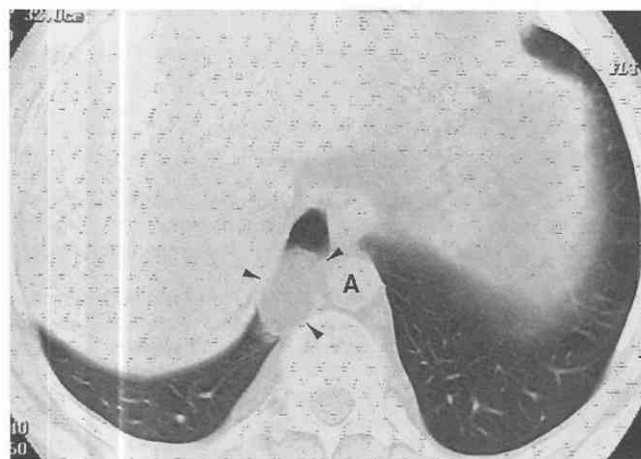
Bochdalek's hernia. CT shows homogeneous fat-attenuation mass (arrowheads) in the right paraspinal location. Location and CT appearance are consistent with a diagnosis of Bochdalek's hernia. A, aorta.
